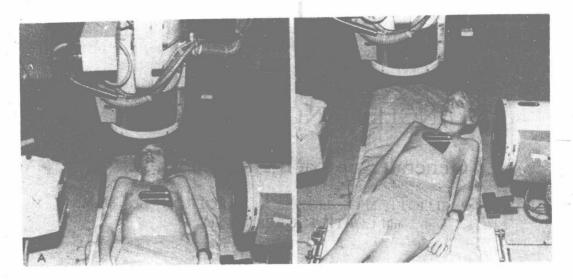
A, The relationship of the x-ray beam (white arrows) and the heart to the lateral x-ray tube, as seen with conventional angiography (fixed anteroposterior and lateral tubes). When the beam is not perpendicular to the long axis of the heart, there is always foreshortening of the ventricles, which obscures certain intracardiac structures, especially the left ventricular outflow tract and septum. B, The relationship of the lateral x-ray beam and heart to the lateral tube, as seen with axial alignment. One method of obtaining this angle is to slant the patient on the table in order to position the long axis of the heart perpendicular to the x-ray beam.
